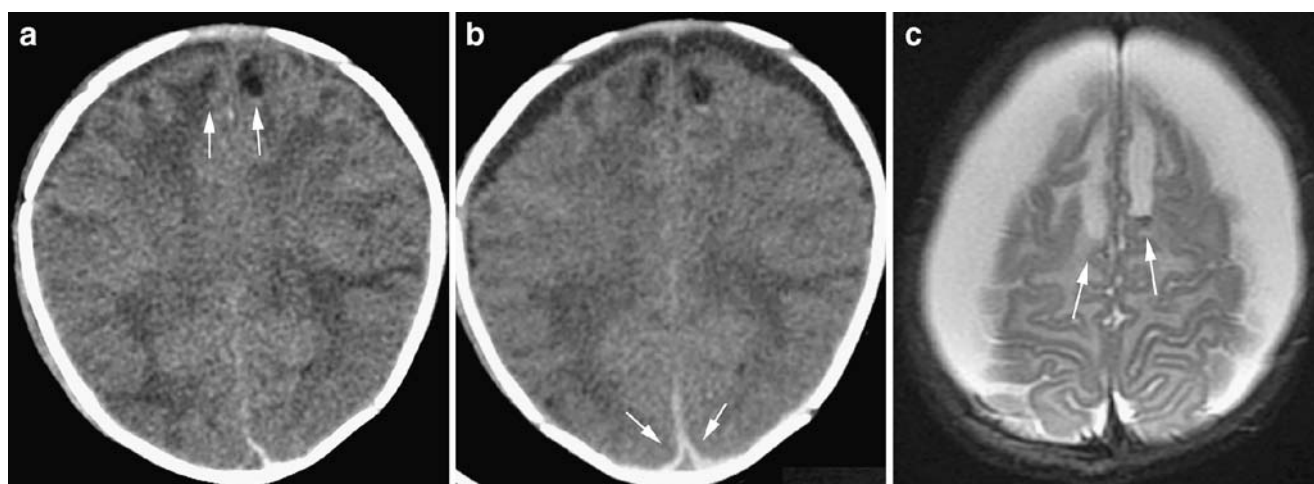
Rapid accumulation of hematoxygroma. CT images obtained on day 1 (a) and day 4 (b), and axial T2-W MR image obtained on day 12 (c) after NAHI. Accumulating, acute, low-attenuation subdural collections are evident around the frontal convexities. An increasing
